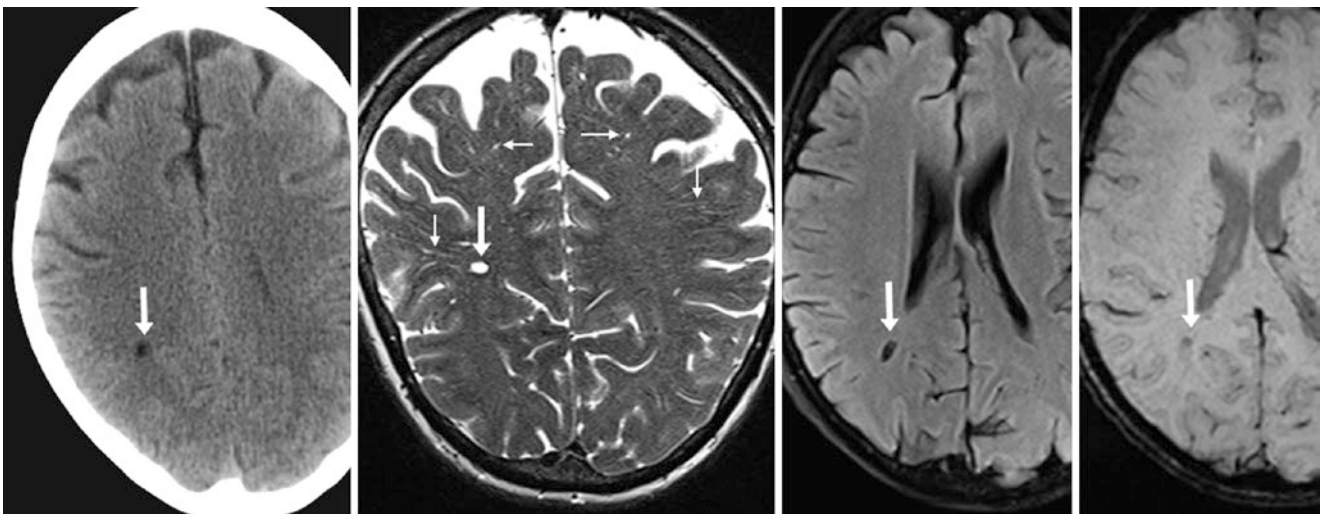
A 57 year old had a single dilated PVS (*arrows*) within the right parietal PVWM adjacent to the lateral ventricle on NECT (*left*). On a 3T MRI, it was hyperintense on a coronal T2WI (*left middle*), suppressed on axial FLAIR (*right middle*), and was barely visible on SWI (*right*). This is an example of how PVSs may be solitary and can mimic lacunar infarcts. Thin PVSs are also present on T2WI within the subcortical white matter bilaterally (*tiny arrows*)
